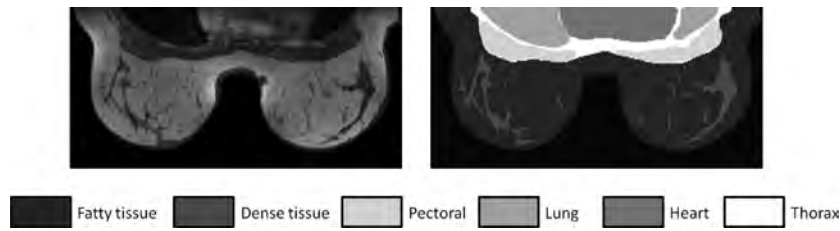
Breast MRI scan on an axial slice with manual annotations of the different structures
